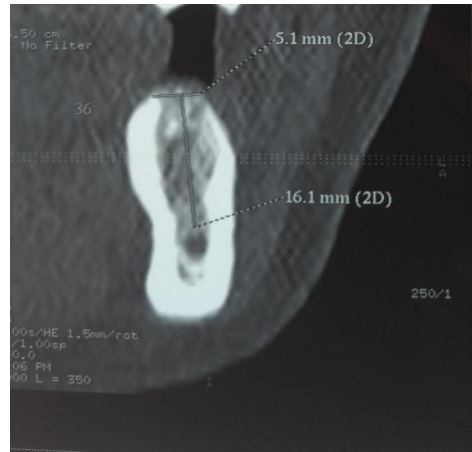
On a CT scan in projection 36, the bone tissue density is D2 (the cortical layer is very pronounced).
